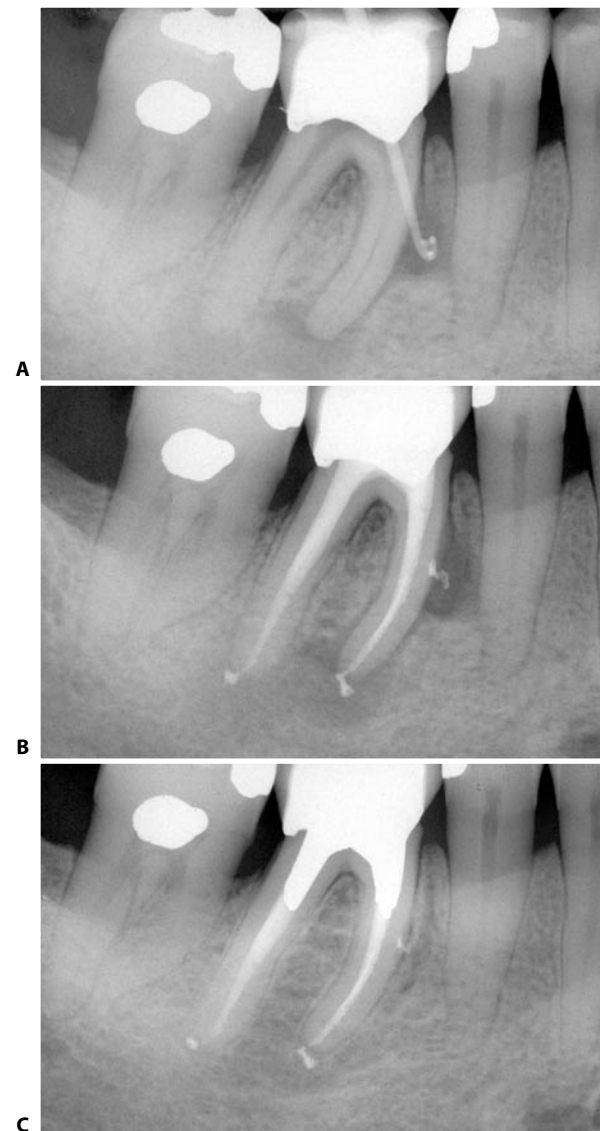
Fig. A. Preoperative radiograph of a lower right first molar: the tooth has a fistula arising from a lateral canal. B. Postoperative radiograph: note the filling of the lateral canal. C. The recall radiograph 24 months later shows the complete healing of both the apical and the lateral lesions.
